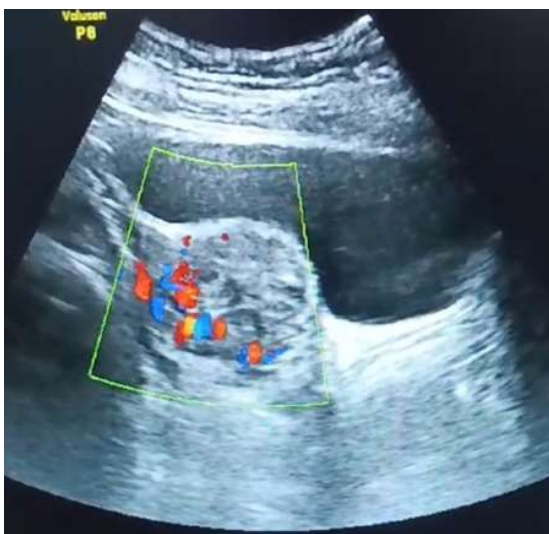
Color Doppler with the feeder vessel.
